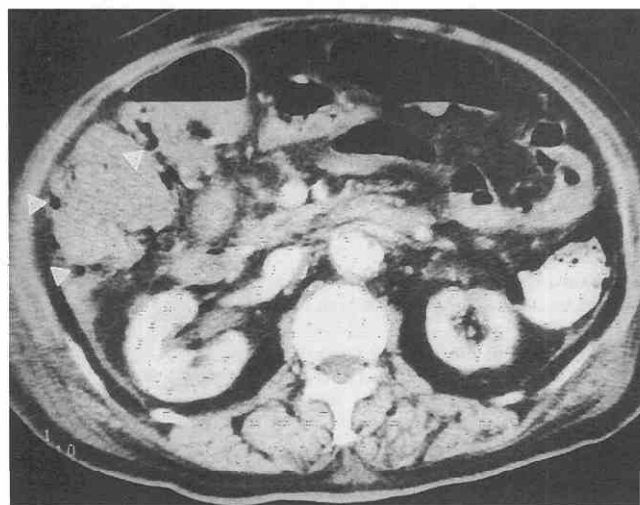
Colonic infarction. CT scan shows intramural gas (arrowheads) in the proximal transverse colon without well-defined bowel wall thickening. (From Ha HK. CT in the early detection of strangulation in intestinal obstruction. *Semin Ultrasound CT MRI* 16:141-150, 1995.)
